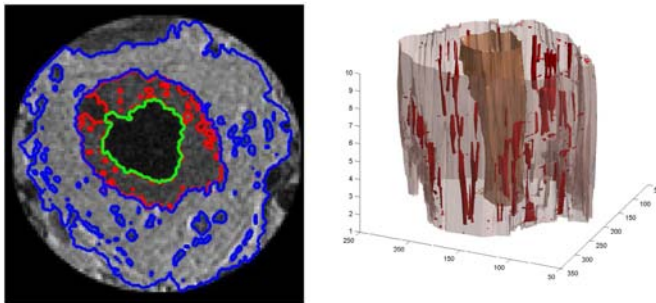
Left: Level sets segmentation of a colorectal MR image slice using NPMM-ICLS algorithm, with colour code of green - colorectum, red - tumour, blue - mesorectum. Right: Segmentation of the Mesorectal Fascia in 3D, showing also the colorectum and tumour, blood vessels and lymph nodes within the mesorectum
